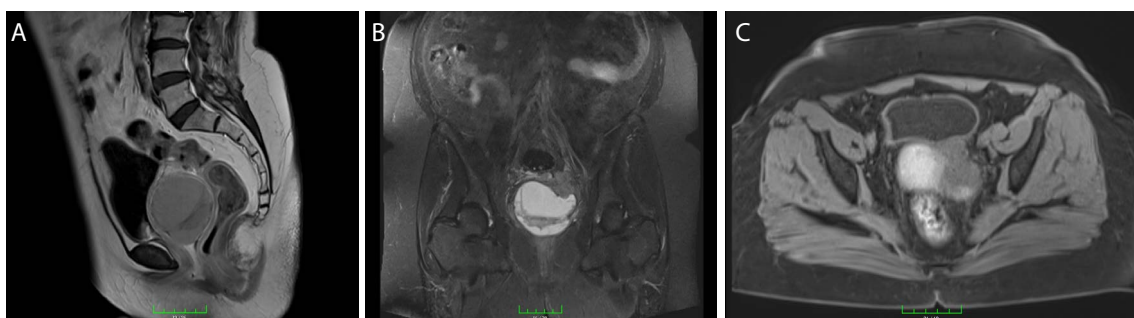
Pelvic MRI showing an 8x6x7 cm cystic lesion in the uterine tumor bed, with solid components (a) sagittal view (b) coronal view (c) axial view.
